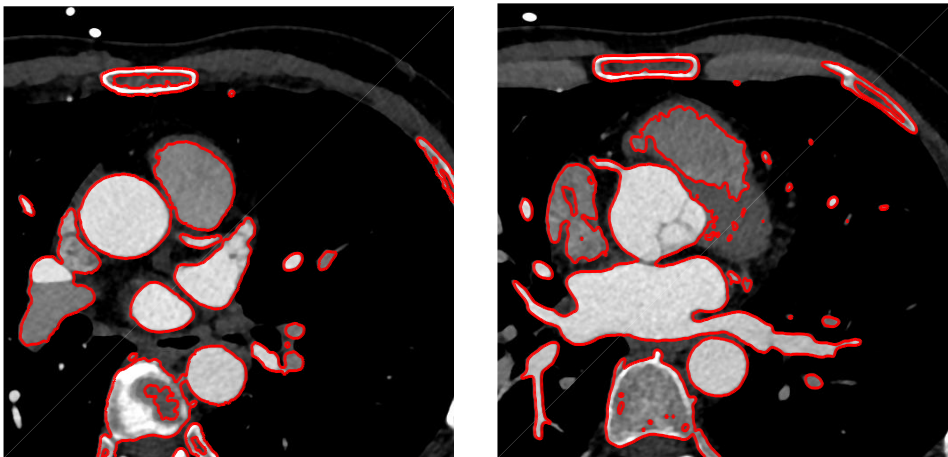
CAD segmentation based on 2D CTA image.
